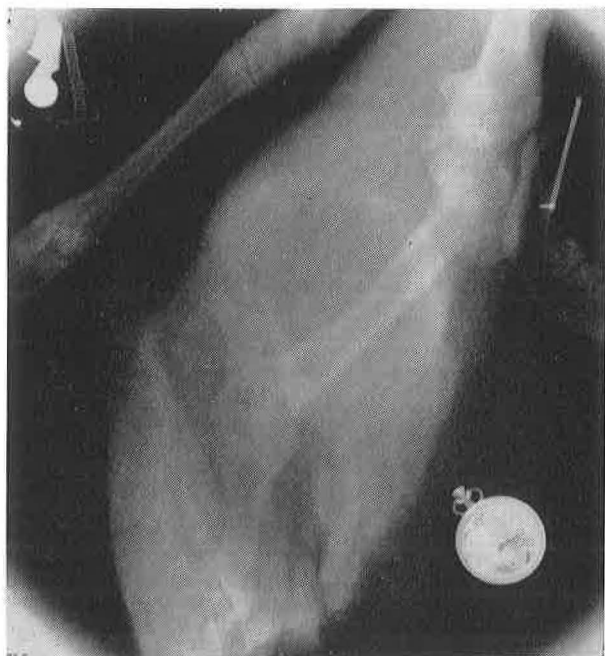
(left). Radiograph of leg of lamb and other objects exposed to a europium-155 source
